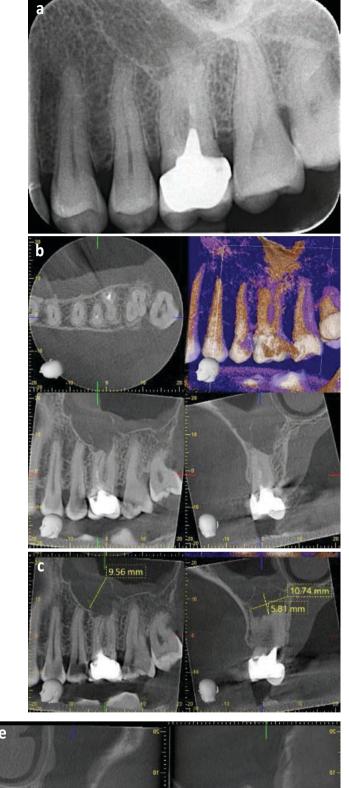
a - preoperative radiograph; b - preoperative CBCT; c - measurement of the lesions; d - postoperative radiograph; e- follow-up CBCT
